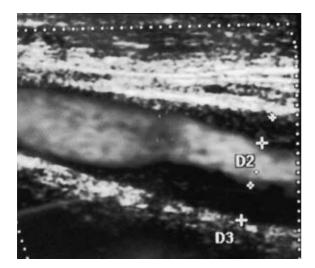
Doppler ultrasonography shows stenosis of the left internal carotid artery and a hypoechoic atherosclerotic plaque. Right side: rostral, left side: caudal.
